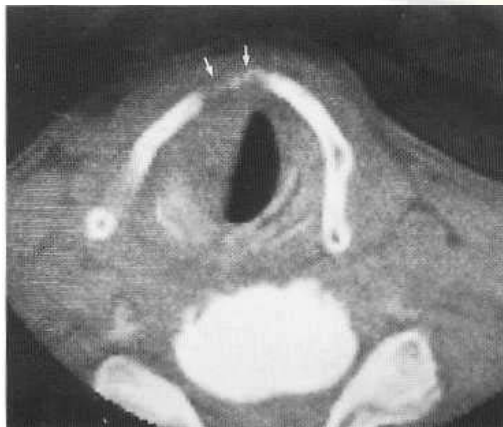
CT section just below the true cords shows a squamous carcinoma distorting the normal oval shape of the subglottic airway and eroding the thyroid cartilage anteriorly (arrows).
